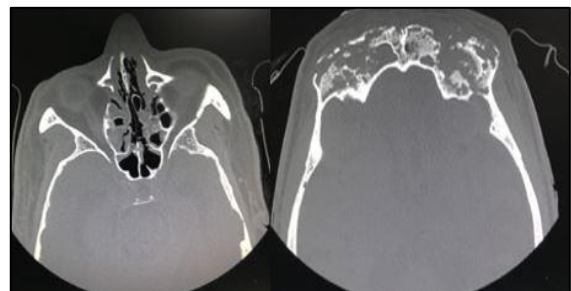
Contrast enhanced CT Scan of a patient showing features of soft tissue opacification of bilateral frontal and ethmoid sinuses with associated fragmented bony destruction and remodelling/sclerosis of frontal bone with multiple intraosseous air foci.
